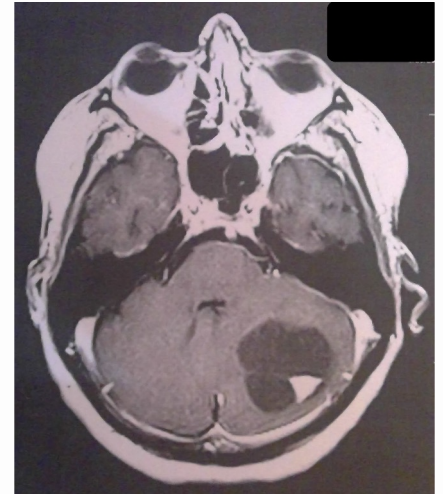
MRI Brain with Perfusion
